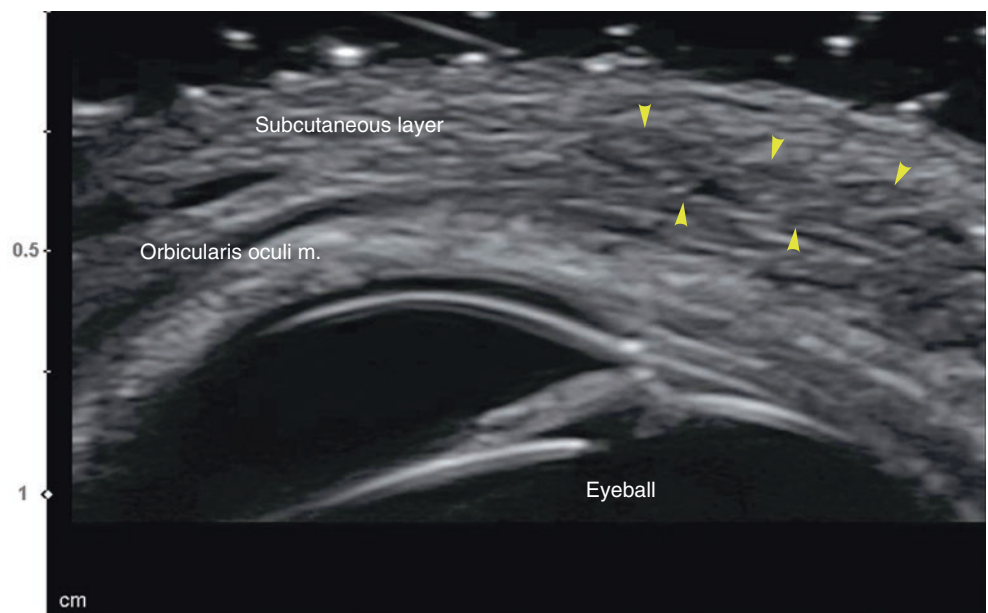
Ultrasonography of the HA filler for the sunken eye augmentation, B mode (transverse view, 15 MHz by linear transducer) (yellow arrowheads: HA filler). (Published with kind permission of © Ji-Soo Kim 2020. All Rights Reserved)
